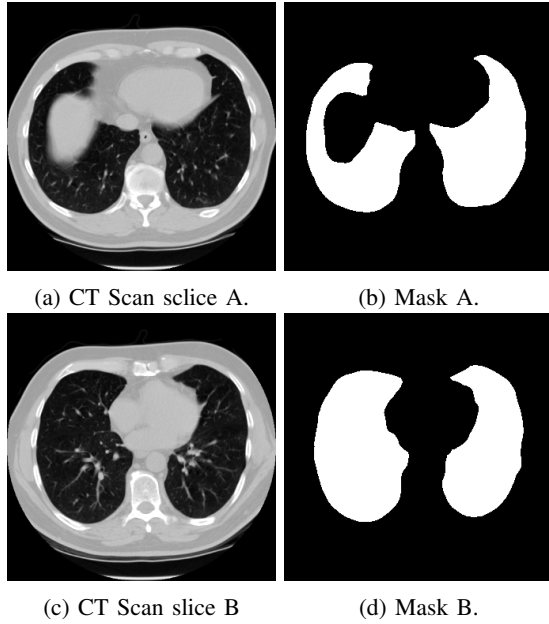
Two slices of CT Scan and their corresponding masks.
